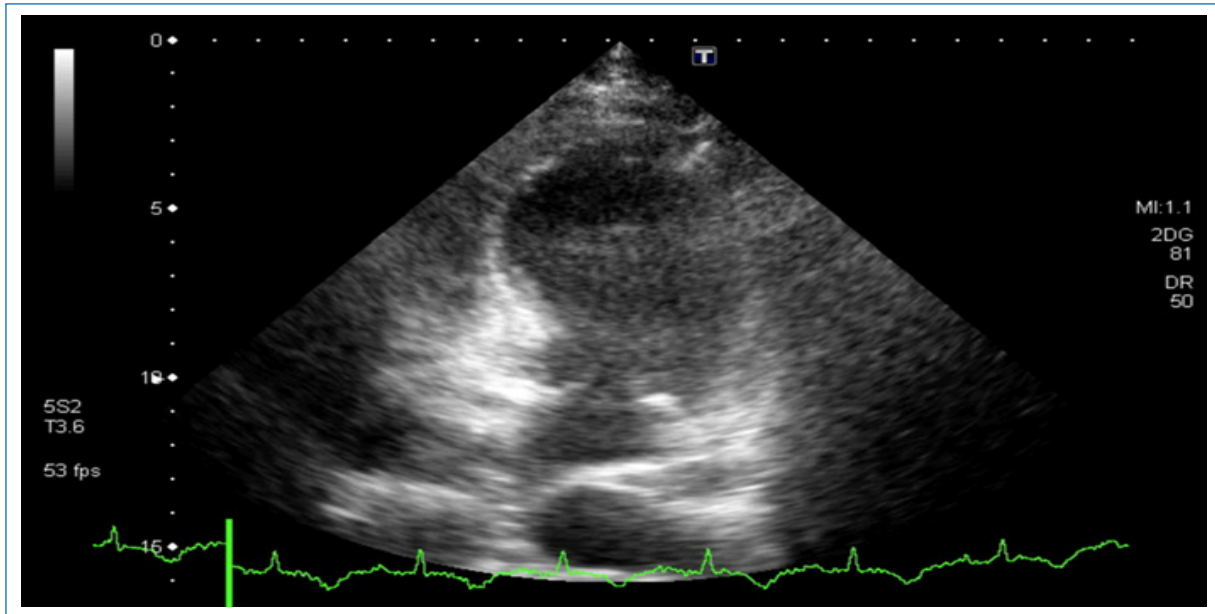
Transthoracic end-systolic four-chamber apical view showing a non-dilated left ventricle with apical and midventricular akinesis and hyperkinesis of the basal segments. Left ventricular systolic function was severely impaired, while the right ventricle size and function remained normal.
